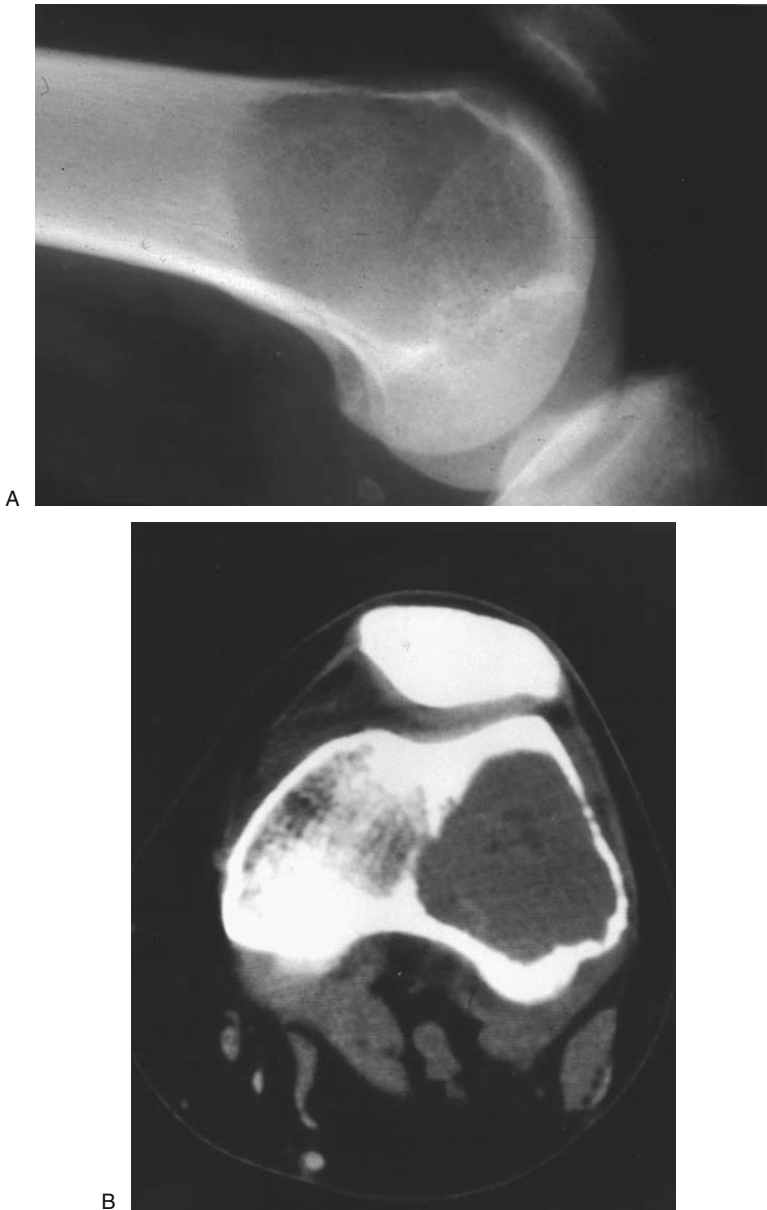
Giant cell tumor. (A) Plain lateral photograph demonstrates a giant cell tumor (GCT) of the distal femur; this is an aggressive expansile, lytic lesion that has thinned the cortex on the anterior portion of the bone. GCTs typically arise from the metaphyseal–epiphyseal junction in skeletally mature patients. This radiograph shows no evidence of matrix formation, as would be expected for an osteosarcoma, which frequently arises from the same location. The distal femur is the most common site for GCTs. (B) CT scan of the distal femur demonstrates a GCT of the distal femoral condyle. The cortices are thin, although there is no evidence of pathologic fracture or soft tissue extension.
